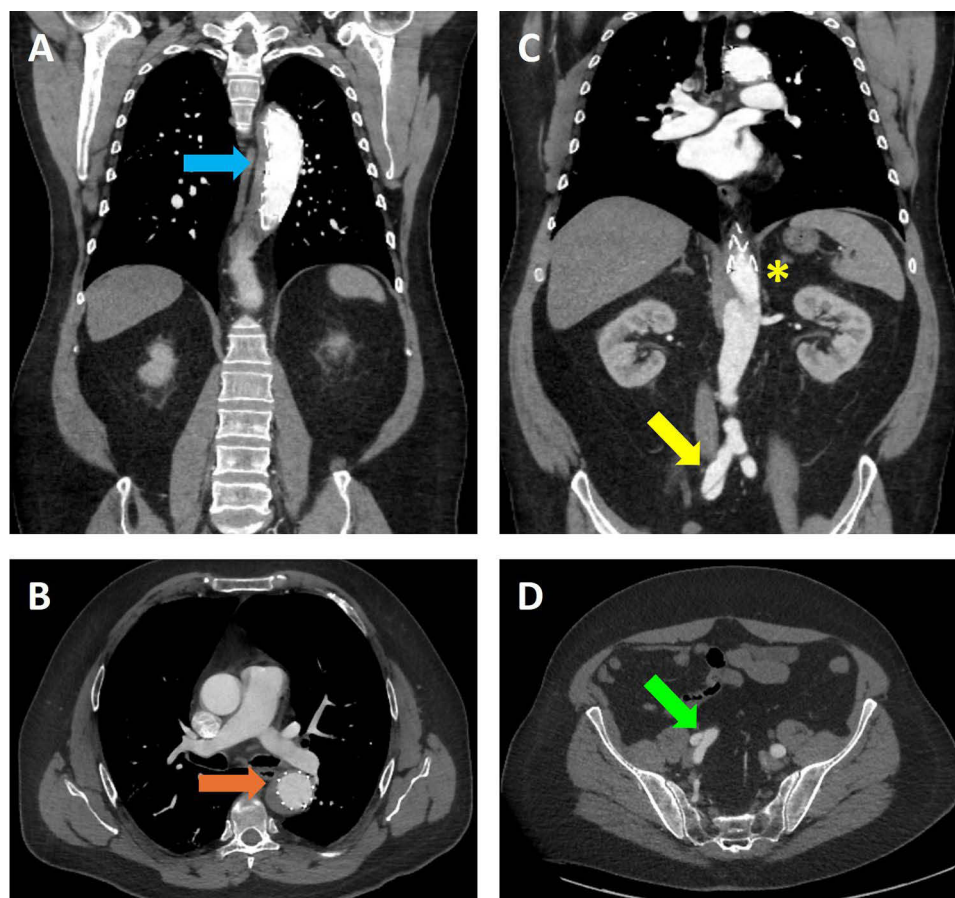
(A) Coronal reconstructed image of angiogram via CT with intravenous contrast showing type B descending aortic aneurysm arising from the left subclavian artery. Endovascular stenting is visualized with thrombosis of the false lumen in the thoracic region (blue arrow). (B) Axial image of contrast-enhanced CT, again demonstrating the presence of an endovascular stent and partial thrombosis of the false lumen (orange arrow). (C) Coronal reconstructed image of angiogram via CT with intravenous contrast demonstrating both termination of the endovascular stent at the level of the diaphragmatic hiatus (yellow asterisk) and the presence of a false lumen that extends down to the right iliac artery (yellow arrow). (D) Axial image of contrast-enhanced CT, again demonstrating extension of the false lumen to the right iliac artery (green arrow). Abbreviation: CT, computed tomography.
